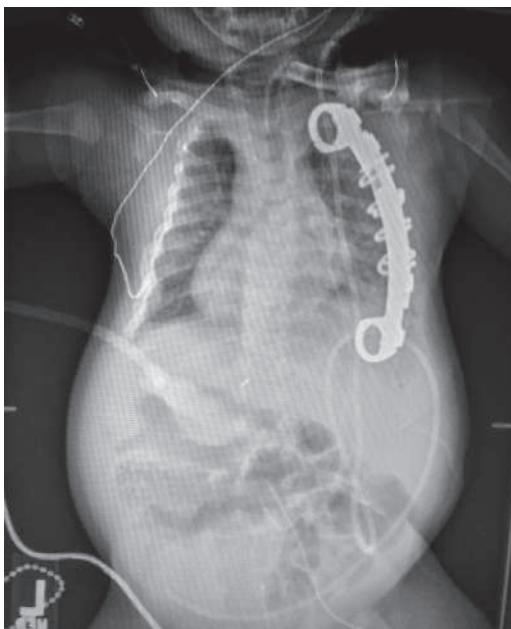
A postoperative posteroanterior radiograph of a patient with Jeune syndrome after placement of a right rib-to-rib VEPTR (vertical expandable prosthetic titanium rib).
